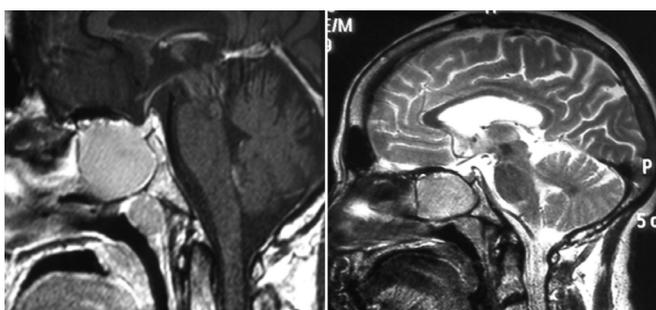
MRI examination (Sagittal views) on T1 and T2 weighted images showing a hyperintense sphenoid sinus mucocele
